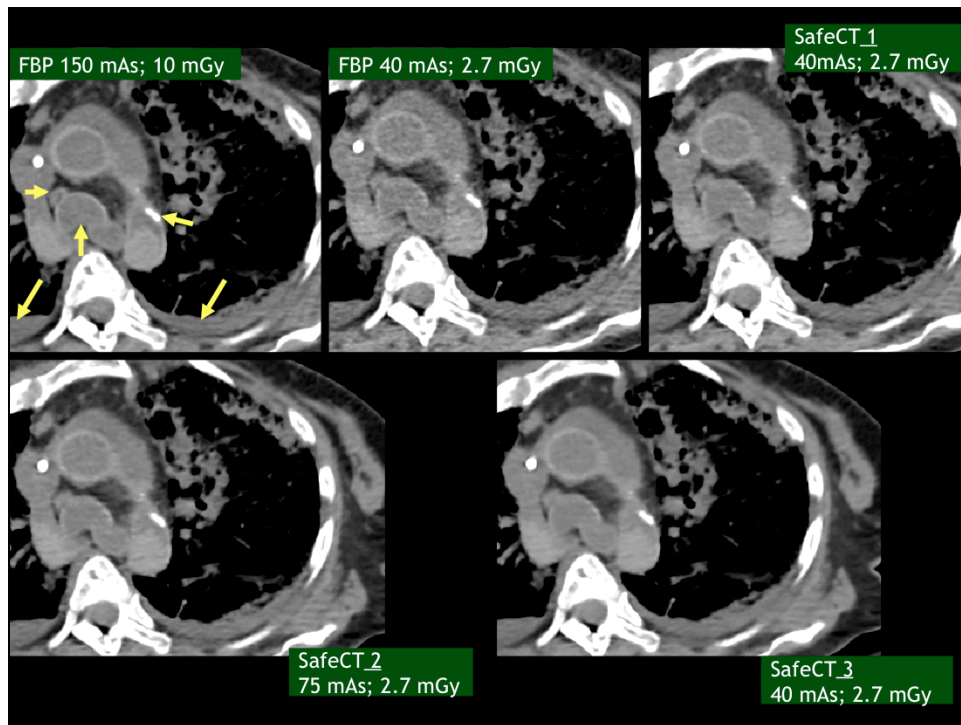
Transverse chest CT images (mediastinal windows) showing paratracheal lymph node, fluid
